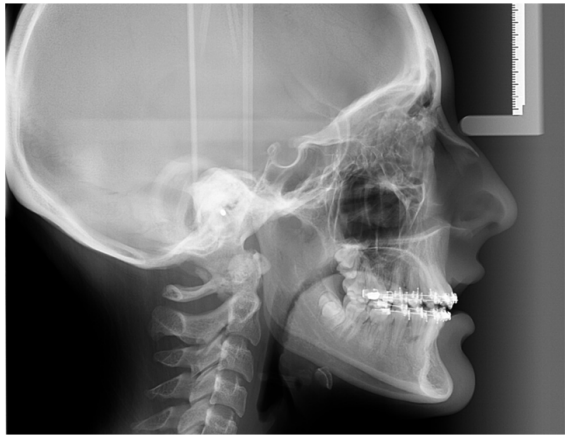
After treatment radiographs.
